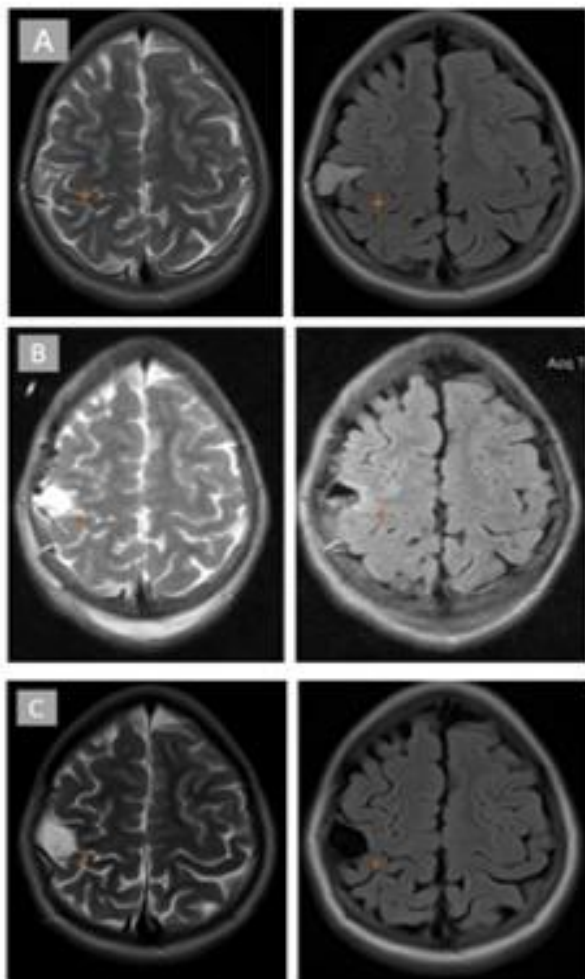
28 years old female with right prerolandic oligodendroglioma (A-C) has presented with Jacksonian seizures which became drug resistant 2 years after the onset. She was operated using and IOM. Postoperatively she installed left brachial paresis even though intraoperative no cortical motor response was found at direct cortical stimulation (D). She slightly recovered the motor deficit at one year follow up. (A) preoperative head MRI: T2 and FLAIR weighted-images, the star – Rolandic area. (B) postoperative MRI hypersignal in hand area. (C) one year follow up images, oedema remission. (D) no motor response (intensity-18mA), standard baseline muscular recordings (biceps brachii, abductor hallucis, tibialis anterior muscle).
